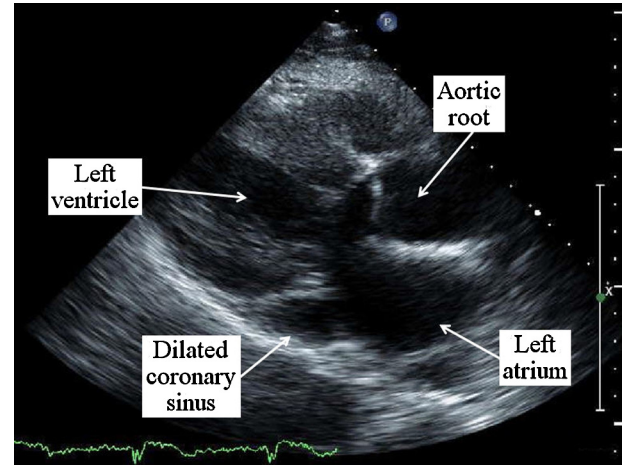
Parasternal long-axis 2D echocardiographic view showing the dilated coronary sinus, which measured 2.5 cm in transverse diameter.
